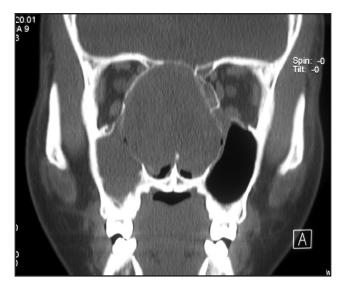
Pre-op CT scan (Coronal View, Bone Window) of paranasal sinuses showing the huge well-encapsulated mass occupying the midline of the nasal cavity. The nasal septum is entirely engulfed by the tumor.
